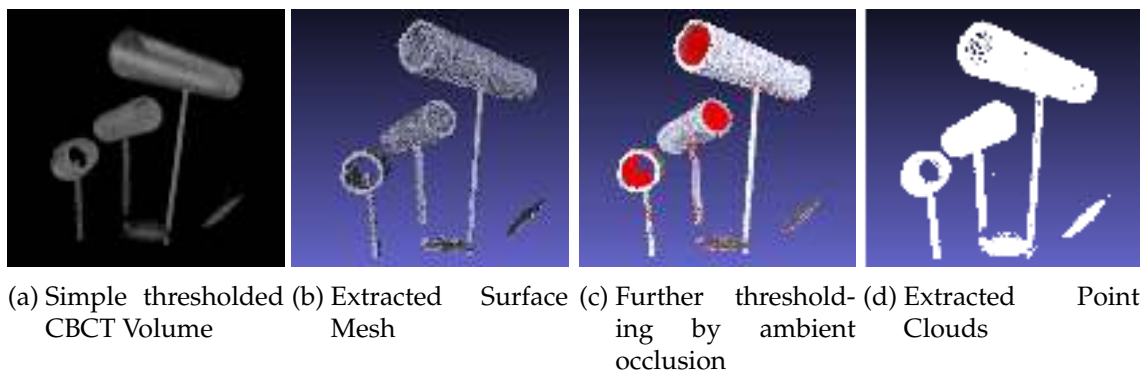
Point Clouds Extraction from CBCT Volume.
